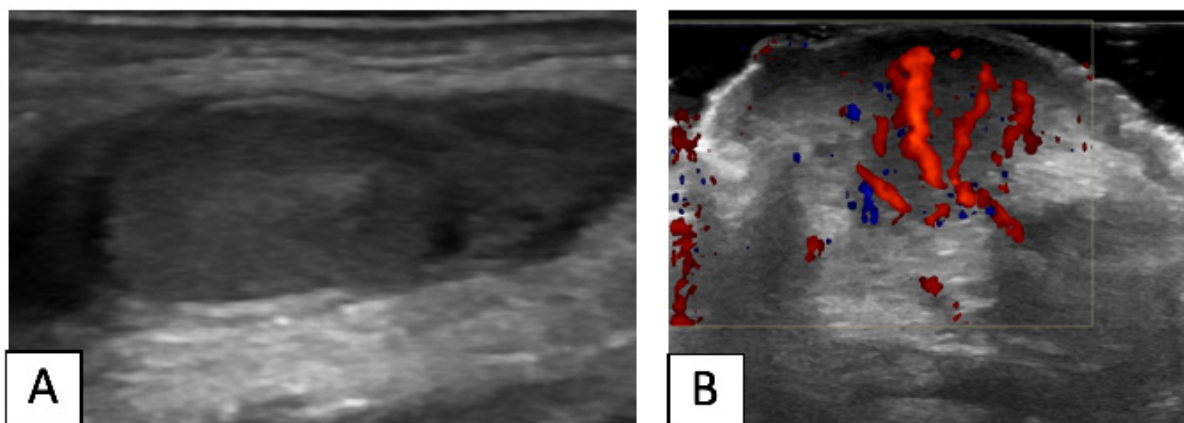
Sonographic images of the left testicle demonstrating normal size, regular borders and homogeneous texture (A) with normal vascular flow (B).
